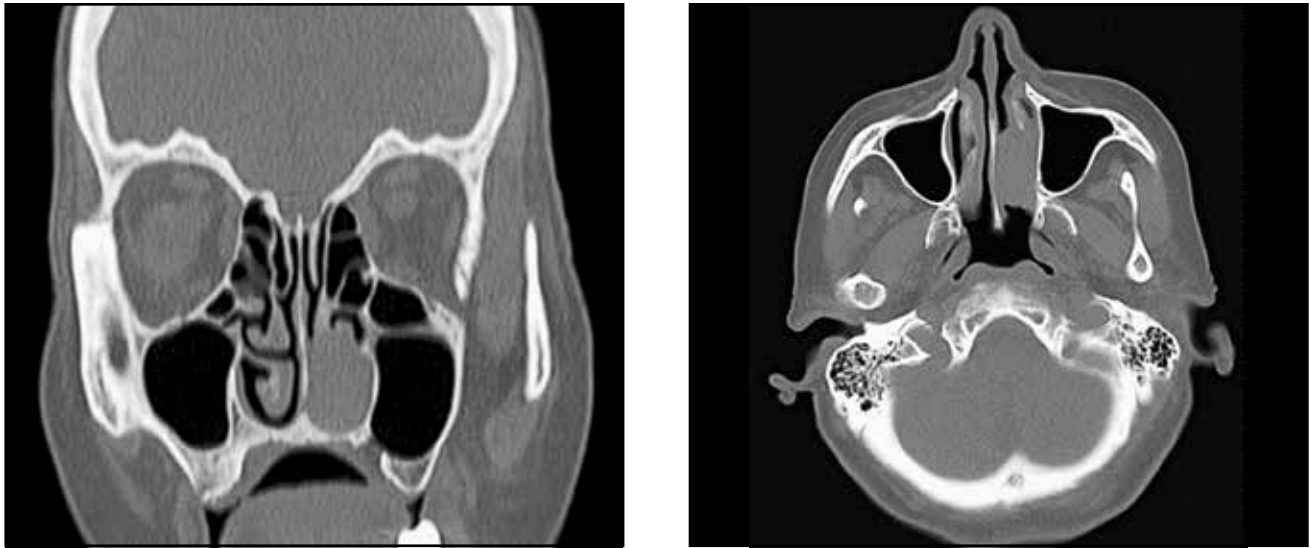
Native craniofacial CT scan, coronal and axial slices - a space-occupying lesion in the left nasal fossa.
